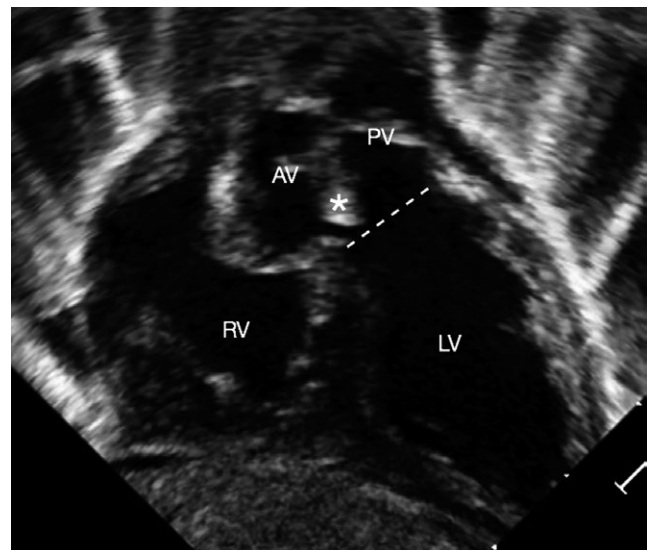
Two-dimensional (2D) transthoracic echocardiographic subcostal long-axis image. The aortic valve (AV) is positioned rightward of the pulmonary valve (PV), separated by a prominent conal septum (white asterisk). The diagnosis was initially misinterpreted as transposition of the great arteries, believing the ventricular septal defect (VSD) was the small communication between the conal septum (white asterisk) and interventricular septum; however, with further imaging planes, along with the aid of computed tomography, the anatomy was understood to be double-outlet right ventricle with the plane of the VSD depicted (white dashed line). LV=left ventricle; RV=right ventricle
